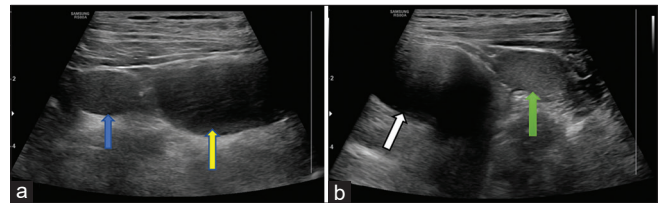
Ultrasound images showing bilateral undescended testes, (a) the right testis (blue arrow) was visualized in the right inguinal region adjacent to the urinary bladder (yellow arrow), (b) the left testis (green arrow) was visualized in the left inguinal region adjacent to the urinary bladder (white arrow)
